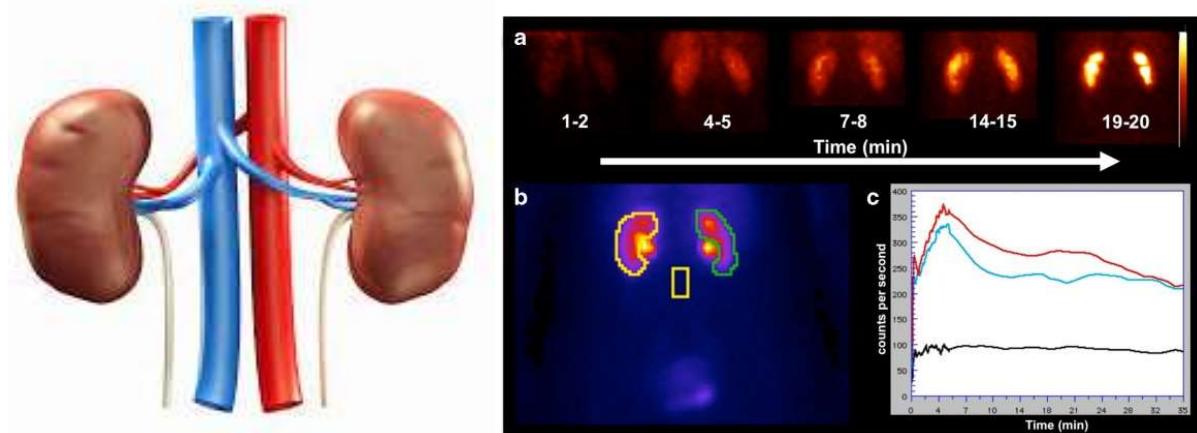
Kidney (left) imaging using SPECT: imaging identifies function of kidneys such as perfusion, filtration and urine formation
